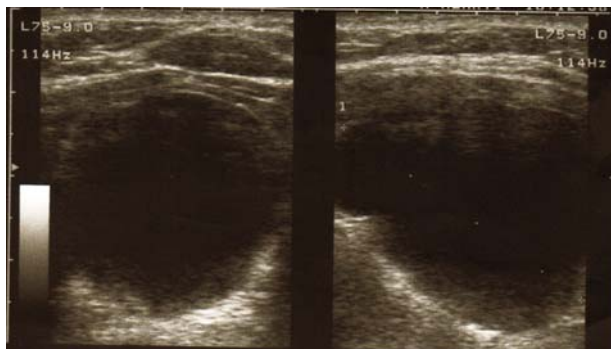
Ultrasound image of the left thyroid lobe – a cyst in the transversal section (left half of the panel) and longitudinal section (right half of the panel).
